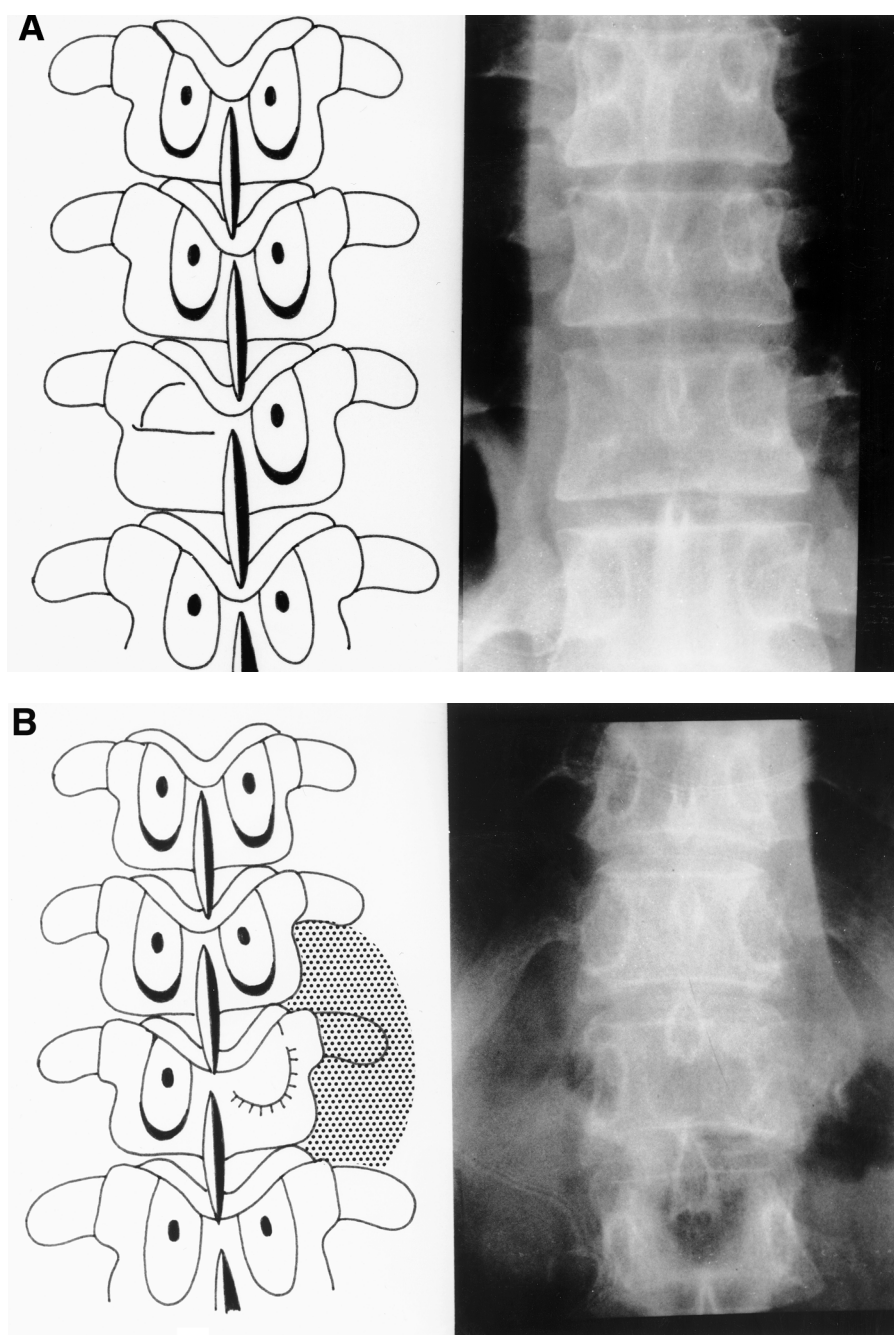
Common bone X-rays of (A) pedicle erosion producing “winking owl” sign; (B) paraspinal soft tissue shadow (with “winking owl”); (C) compression fracture (vertebral collapse); and (D) pathologic fracture dislocation. (*continued*)
